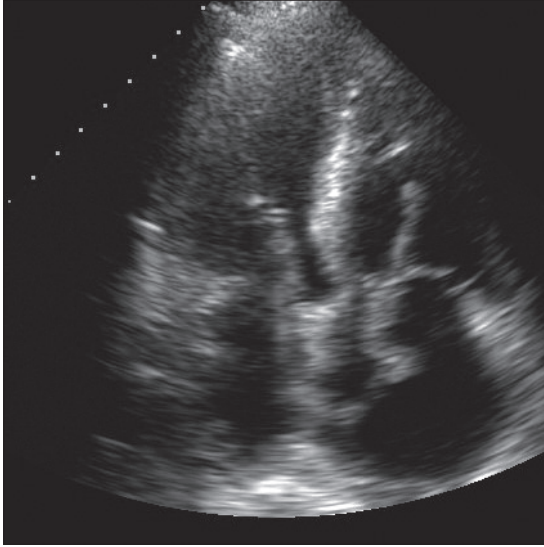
Transthoracic echocardiography view of a biatrial mobile thrombus, entrapped in a patent foramen ovale
